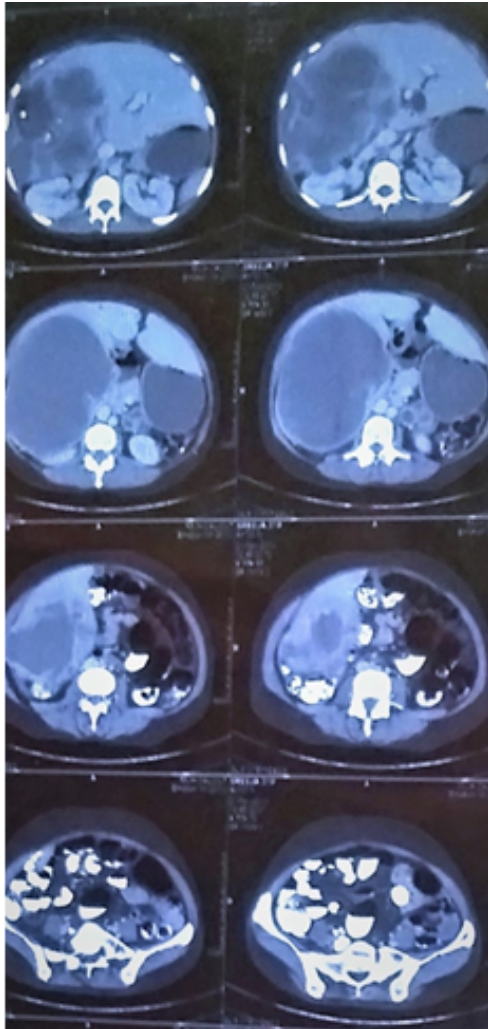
CT abdomen showing heterogeneously enhancing lesion in liver
